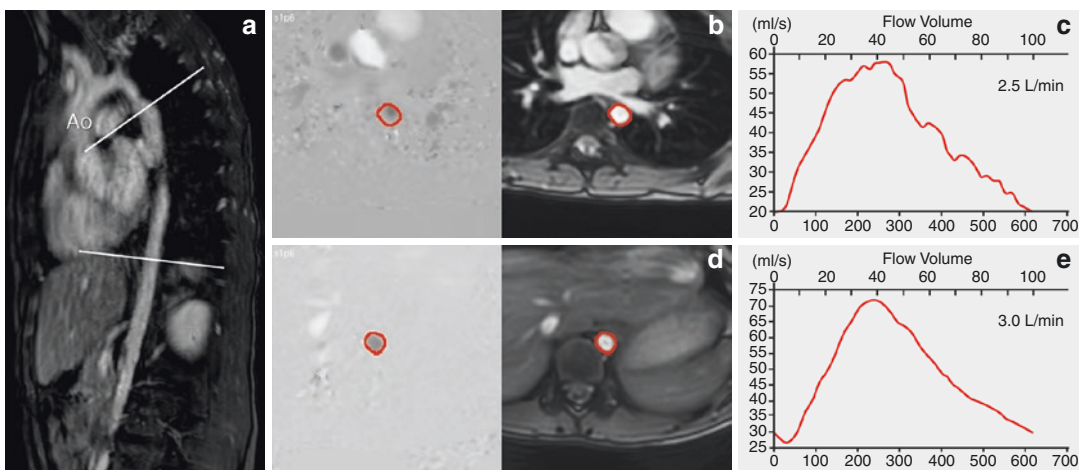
Collateral flow quantification in coarctation of the aorta. Same patient as in Fig 1. MRI flow imaging with phase-contrast technique immediately distal to the coarctation (upper line in (a) and upper row (b) and (c)) and at diaphragm level (lower line in (a) and lower row (d) and (e)).
